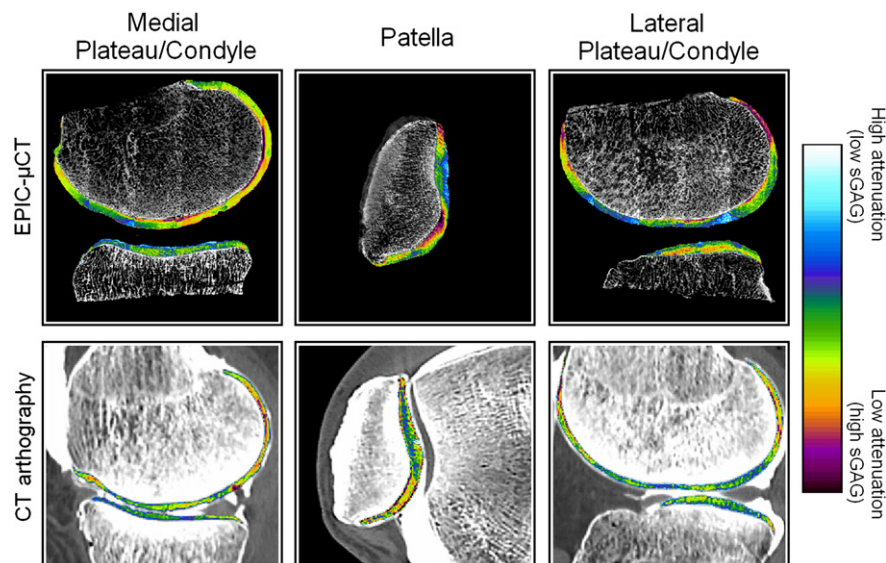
Images of both EPIC- μ CT and CTa. The attenuation of cartilage regions is visualized in colour and representative for sGAG content. High levels of attenuation represent a low sGAG-distribution.
